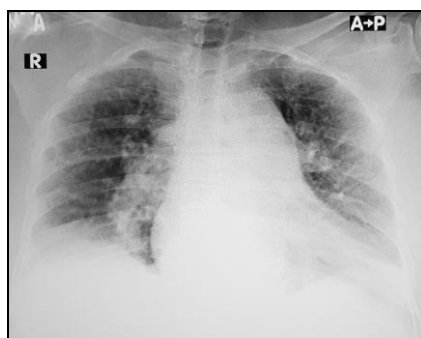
Chest radiograph on day 3 after TKA showed nonspecific infiltrates with right lower base blunting of costophrenic angle.
